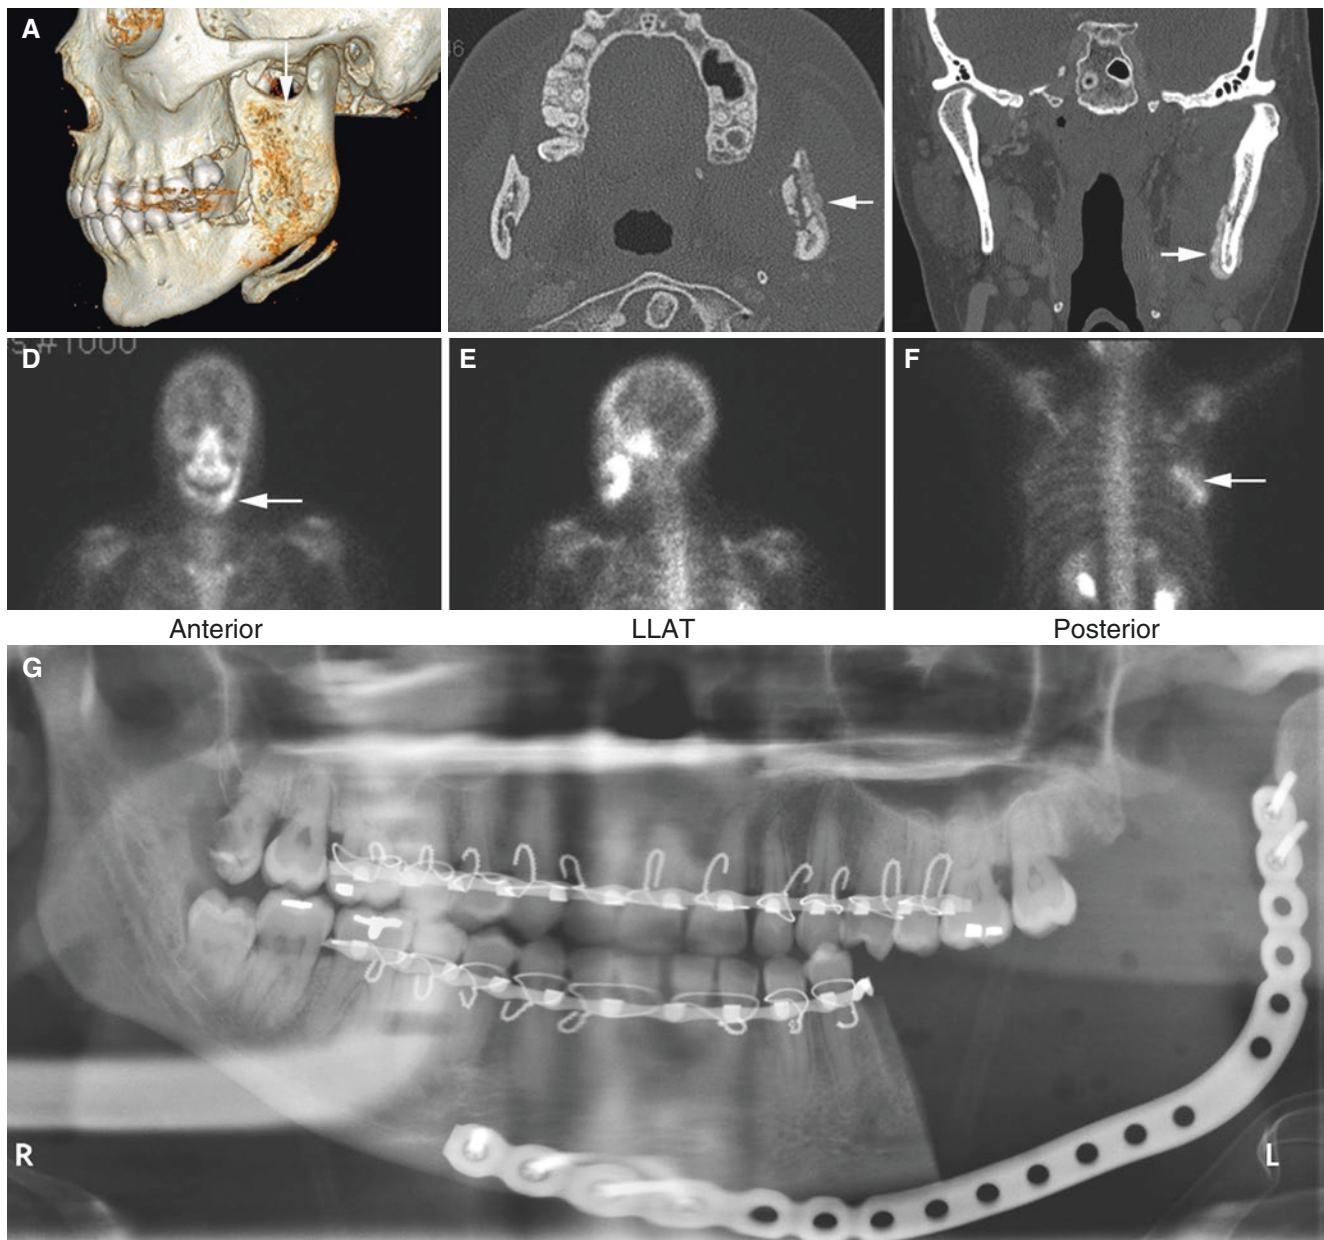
Breast cancer metastasis, mandible; 46-year-old female with mass in the left mandibular ramus. (A) 3D, (B) axial, and (C) coronal CT images show irregular bone (destruction and apposition) in the left
